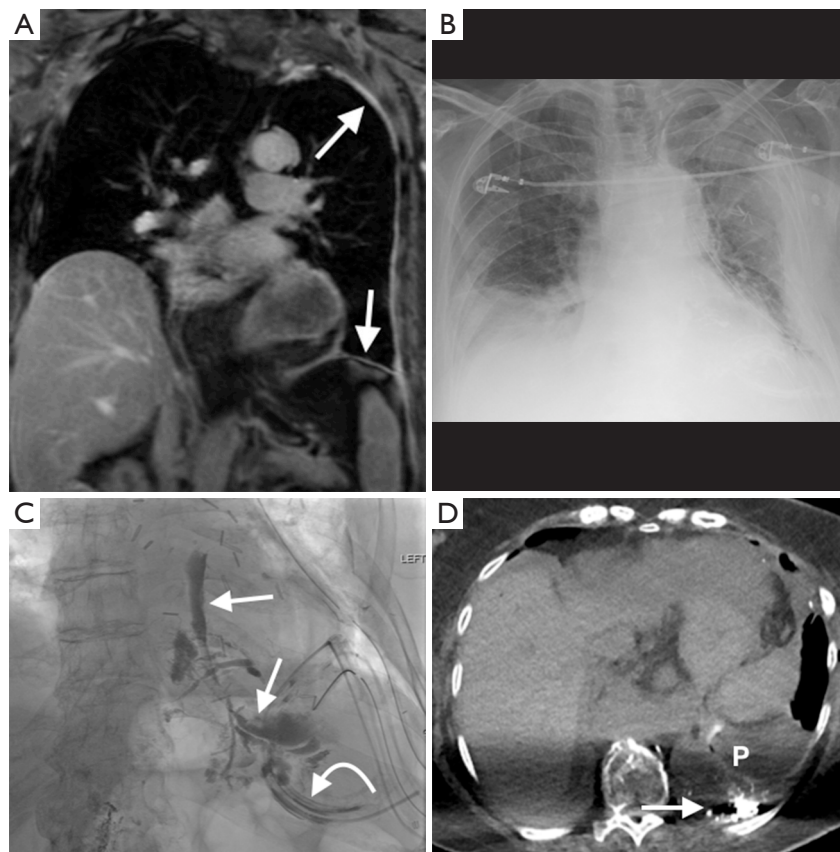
A 77-year-old woman with a left epithelioid mesothelioma underwent a left EP/D with diaphragmatic reconstruction. Coronal image from pre-operative fat-suppressed T1 weighted post-gadolinium sequence (A) demonstrates enhancing left circumferential nodular pleural thickening (arrow). In the early post-operative period, there was high fluid output from left pleural drain with a high triglyceride content, concerning for a chyle leak. A CXR on post-op day 10 (B) demonstrates a left hydropneumothorax with a left chest tube in situ. Frontal spot radiograph from a subsequent lymphangiogram (C) post inguinal lymph node 15ml lipiodol injection demonstrates layering extravasation into the left hemithorax (arrows) consistent with a chyle leak. Note lymphangiographic contrast material draining via the left inferior chest drain (curved arrow). Axial image from a non-contrast CT thorax (D) demonstrates loculated left pleural effusion (P), with retained lymphangiographic contrast (arrow) in the left hemithorax. Attempted interventional radiology thoracic duct embolization was unsuccessful, and the patient subsequently underwent surgical thoracic duct ligation. EP/D, extended pleurectomy/decortication; CXR, chest radiograph; CT, Computed tomography.
